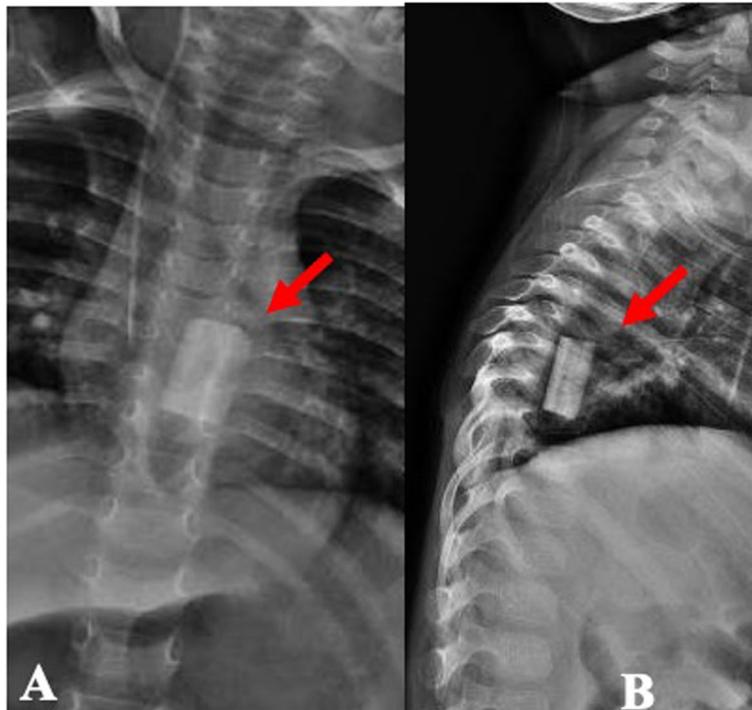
A Ap view and B lateral view of a dorsal spine radiograph post-surgery with fibula allograft (red arrow) between vertebrae D6 and D9
